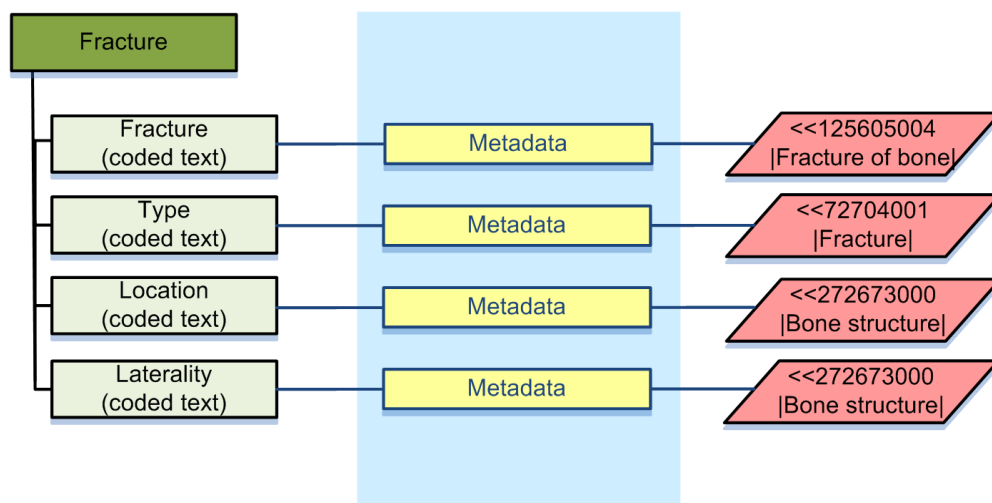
Binding a fracture information model to relevant value sets using expression constraints. <<125605044 |Fracture of bone| means that the valid values are fracture of bone or any subtypes as defined by SNOMED CT. The same goes for the rest of the interpretation of the rest of the expression constraints.
